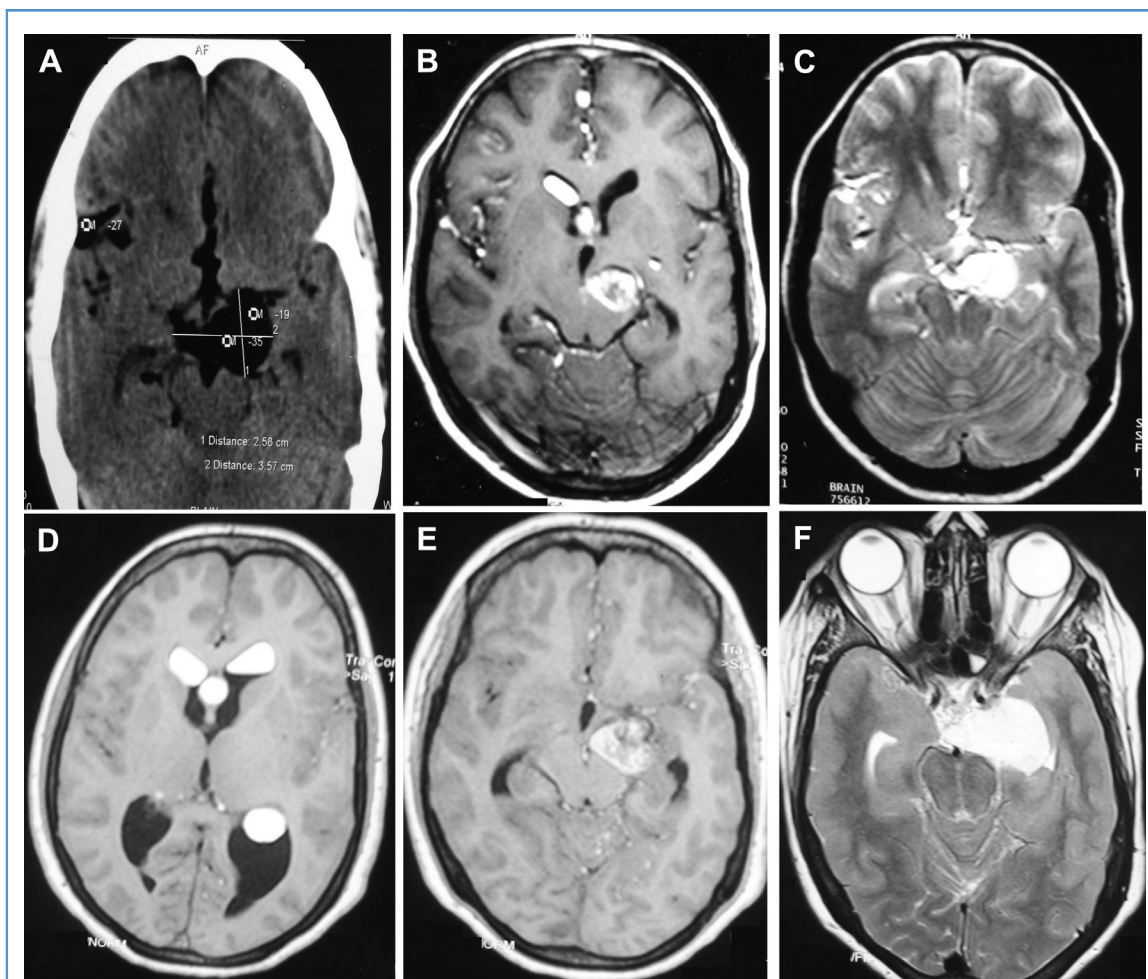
Noncontrast computed tomography (CT) of the head and T1-weighted and T2-weighted magnetic resonance imaging (MRI) show a left parasellar lesion that is (A) hypodense on CT and hyperintense on (B) T1-weighted and (C) T2-weighted MRI with disseminated fat droplets in lateral ventricle, the foramen of Monro, and subarachnoid space. Follow-up MRI after 11 years shows (D) intraventricular hyperintense contents on T1-weighted imaging, (E) parasellar dermoid with moderate enhancement on gadolinium, and (F) hyperintensity on T2-weighted imaging.
